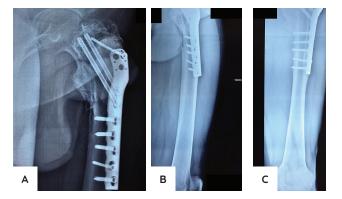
Left hip AP (A) and femur AP (B) and lateral (C) radiographs at 4 years' follow-up.
